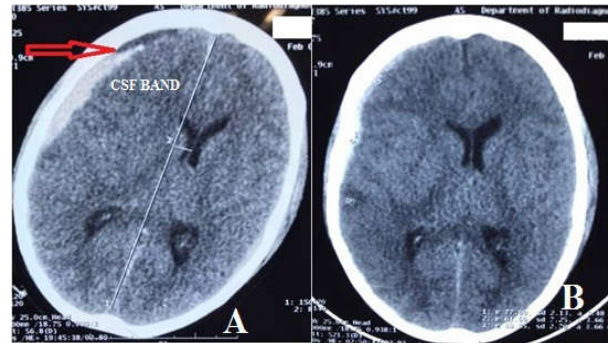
Case no.5 (A) initial CT head showing right side acute SDH and associated CSF band, right temporal contusion, (B) Repeat CT head showing rapid spontaneous resolution of SDH
